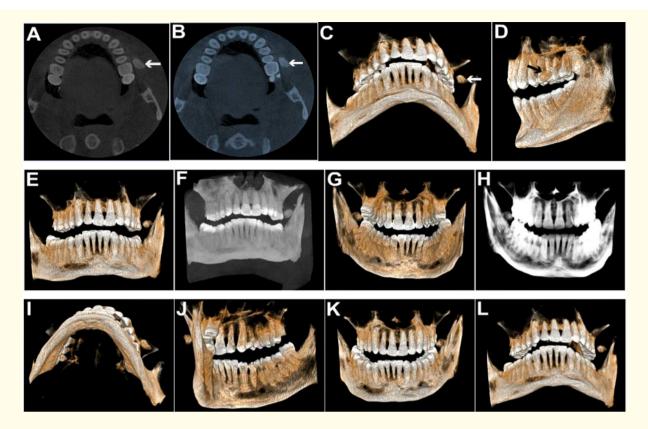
(A-D) Cone beam Computed Tomographic (CBCT) scan of the region revealed a roughly ellipsoid radiopacity indicating a concretion in the region of the buccal space just opposite the crown of the upper first molar tooth (as indicated by the arrows). This was suggestive of a Stensen's duct lithiasis in the distal part of the duct, close to its orifice. (E-L) In addition to 3-D reformatting, the interactive display modes produce accurate inter-relational images in all three orthogonal planes, helping in precisely locating the pathology without superimposition by adjacent bones of the maxillofacial skeleton and with nil artifacts and image distortion.
